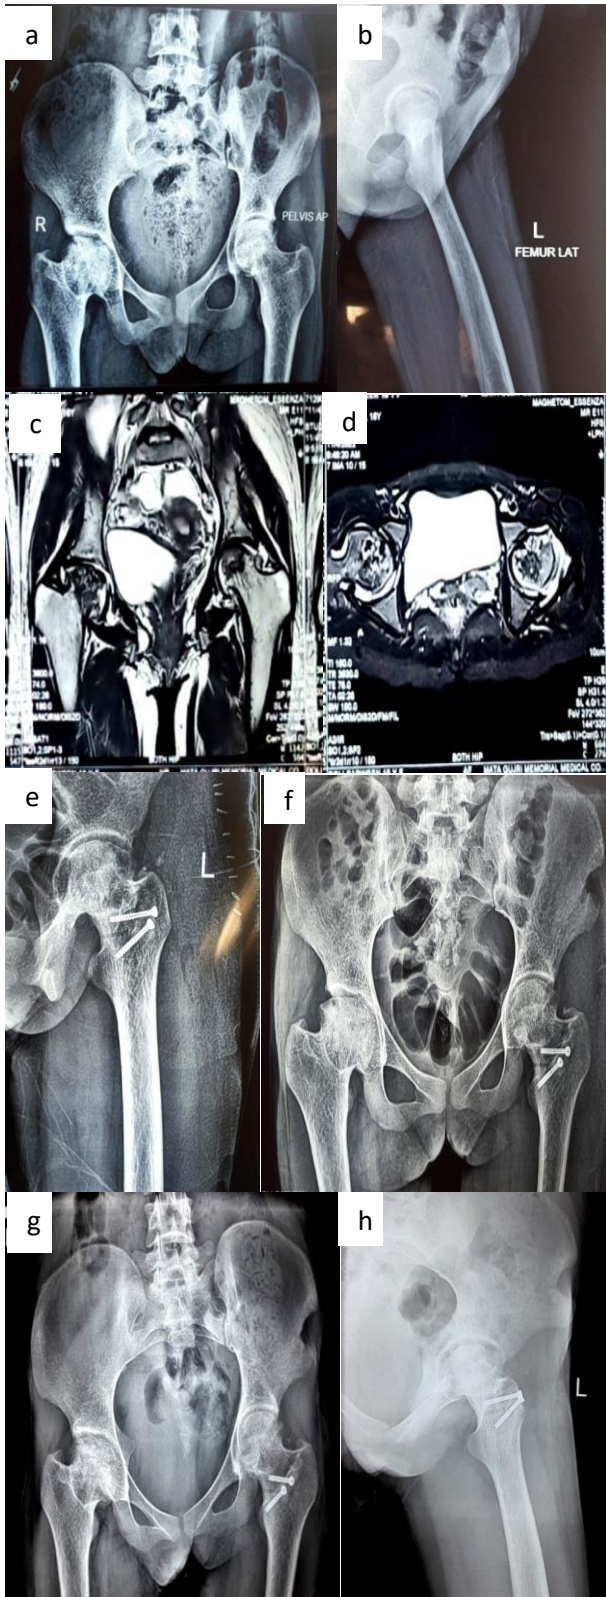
Case 2 radiological follow up images; (a) pre-operative X-ray AP view, Ficat stage III in left side; (b) pre-operative X-ray lateral view; (c) MRI coronal section; (d) MRI transverse section; (e) Follow up X-ray lateral view at 1 year; (f) Follow up X ray AP view at 1 year; (g) follow up X-ray AP view at 2 years; (h) follow up X ray lateral view at 2 years.
